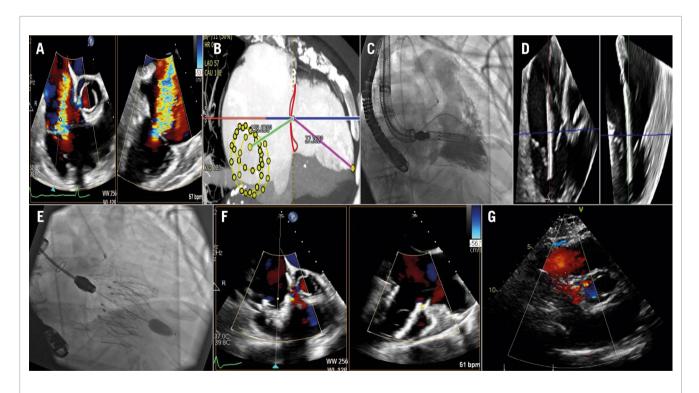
Topaz transjugular TTVR. A) Baseline echocardiography demonstrating torrential TR. B) CT showing IVC-TA offset angle. C) Delivery system with RV angiography. D) 3D echocardiography demonstrating coaxial delivery system. E) Fluoroscopy after valve implantation. F) Echocardiography demonstrating trace paravalvular TR. G) Follow-up echocardiography with trace TR. 3D: three-dimensional; CT: computed tomography; IVC: inferior vena cava; RV: right ventricle; TA: tricuspid annulus; TR: tricuspid regurgitation; TTVR: transcatheter tricuspid valve replacement
